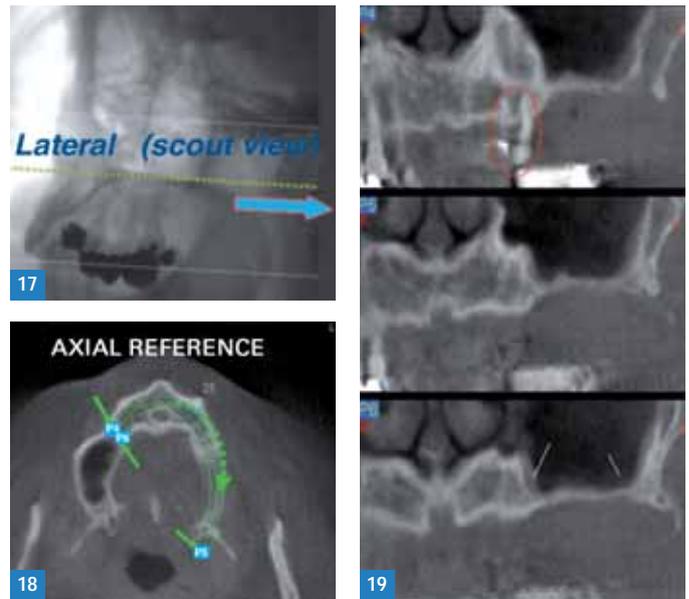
Cone-beam CT: lateral scout view.
